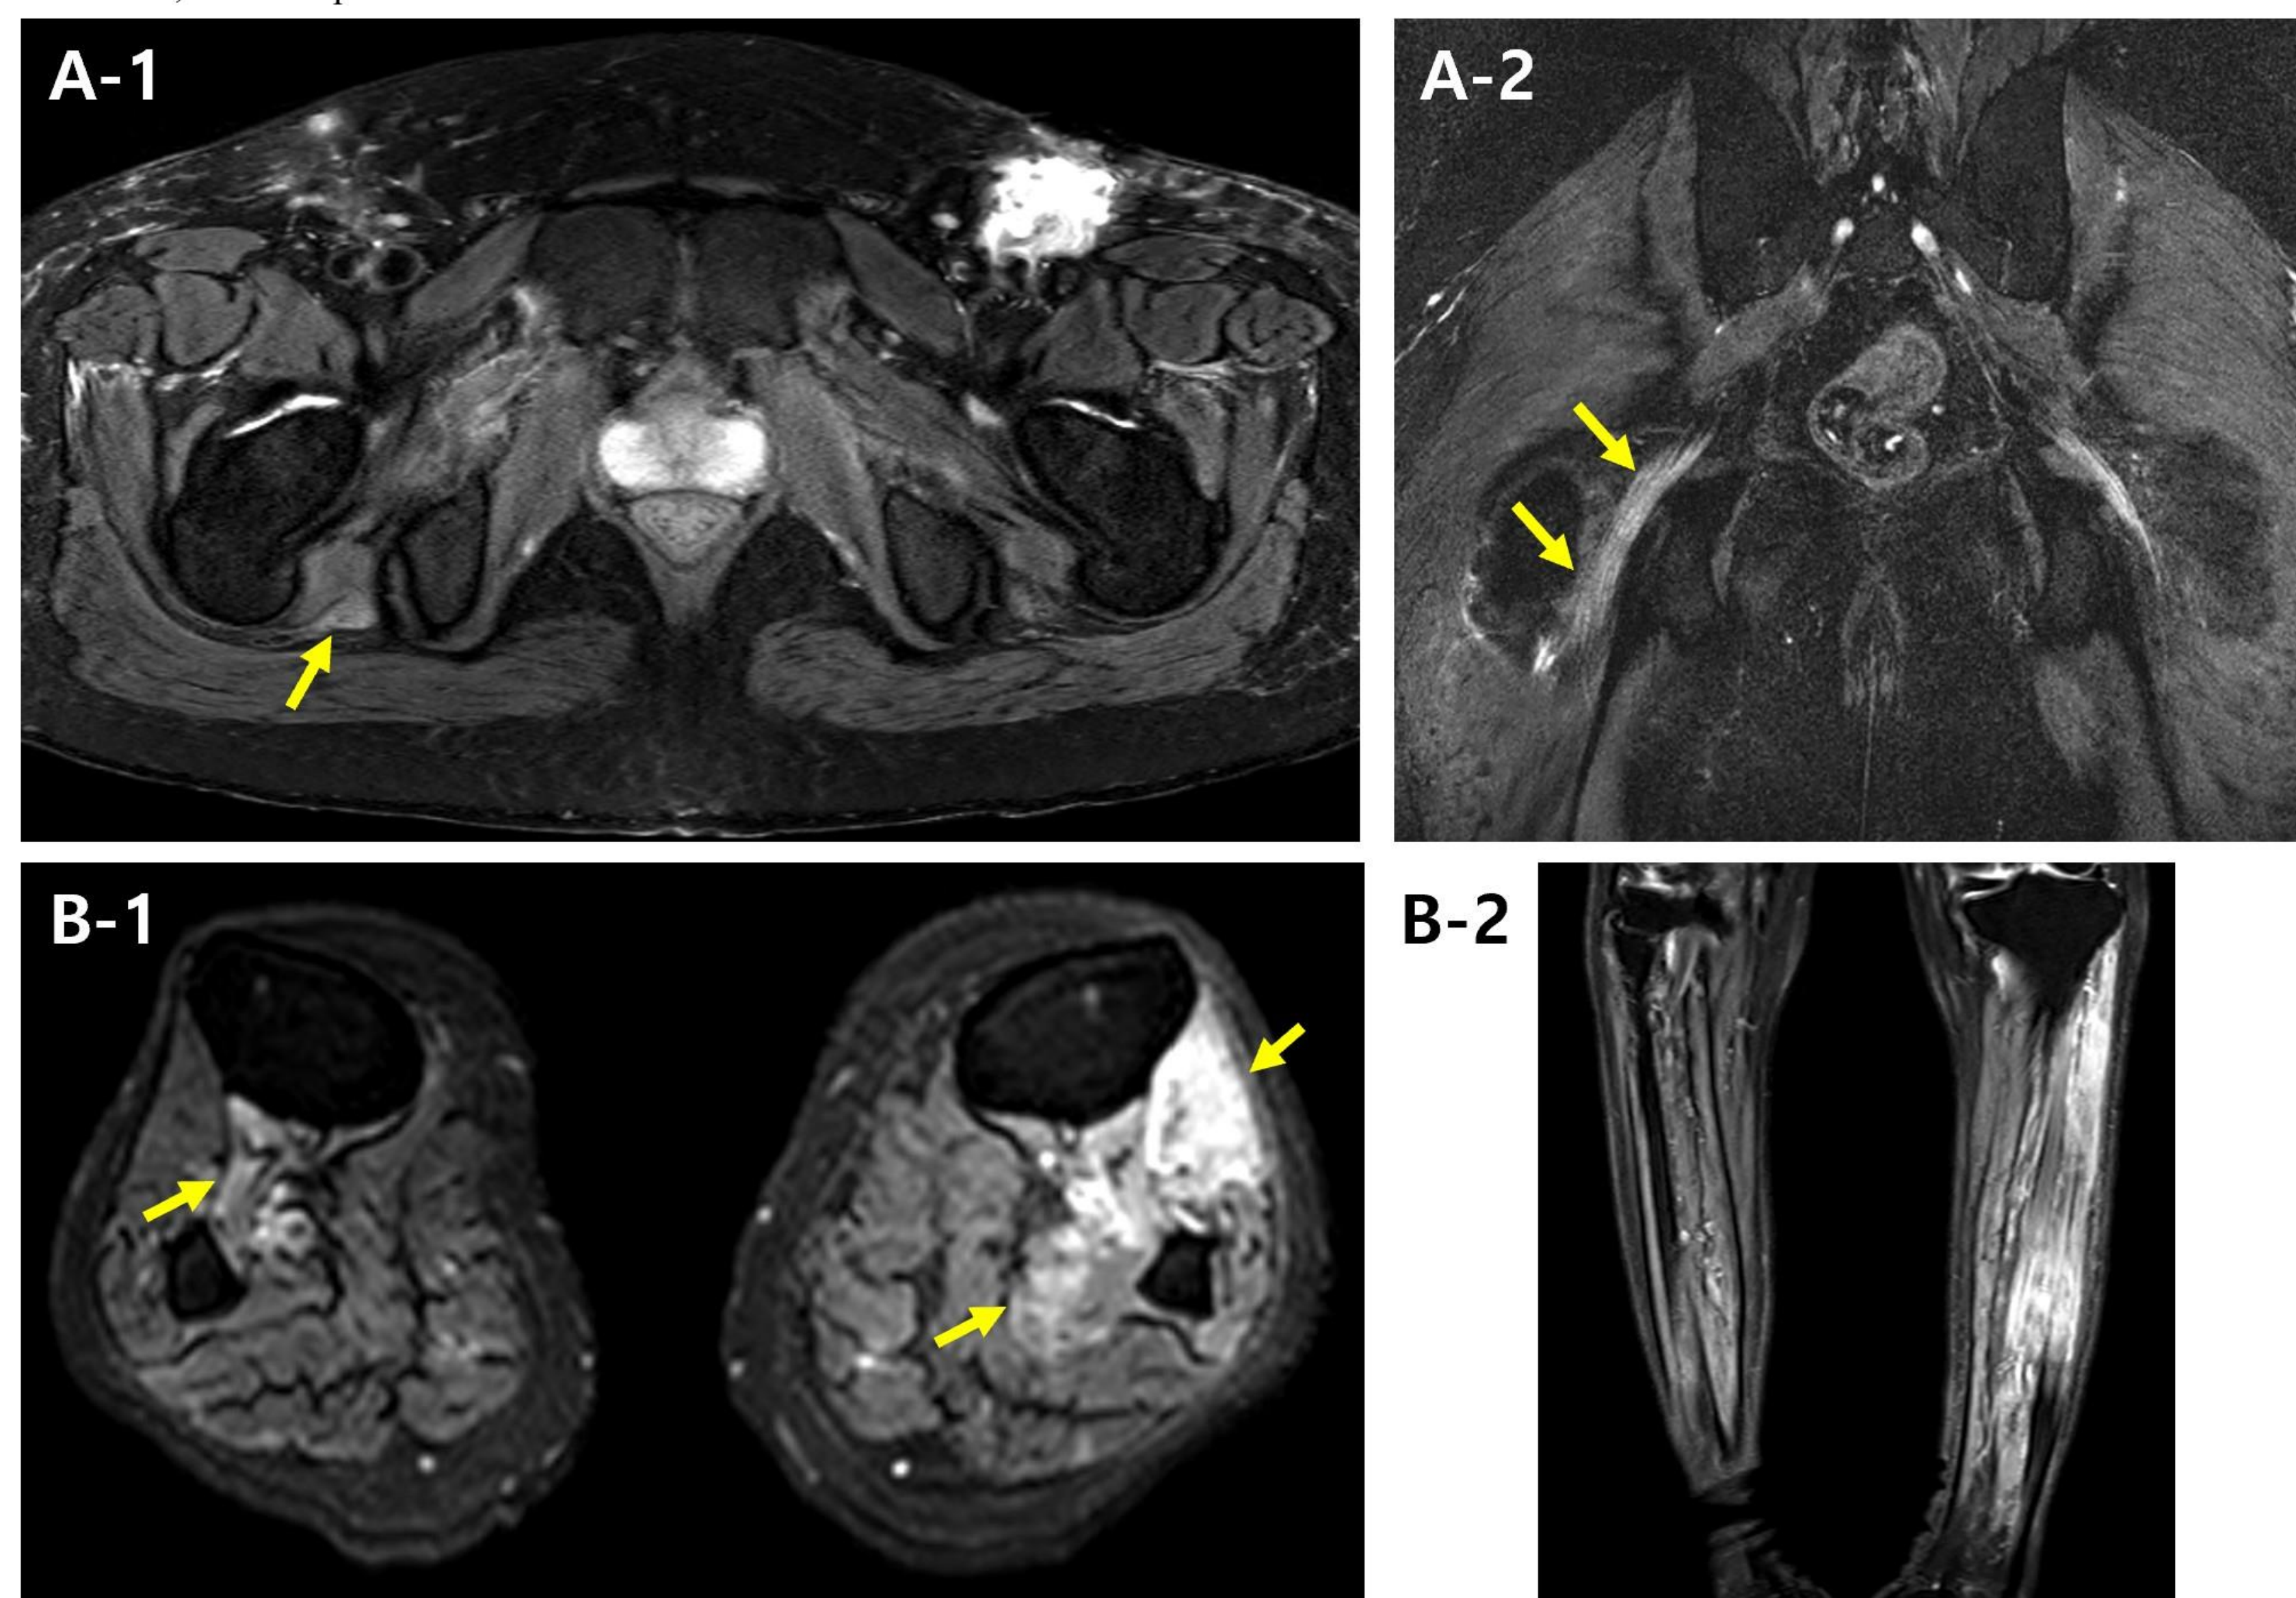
MRI findings of patients in Case 2 (A) and Case 3 (B). (A) Increased T2 signal intensity of the right sciatic nerve in Case 2 is shown in axial (A-1) and coronal (A-2) images. (B) Denervation edema in the anterior and lateral compartment muscles of the left lower leg, as well as the deep posterior compartment muscles of both lower legs, were noted in axial (B-1) and coronal (B-2) images.
